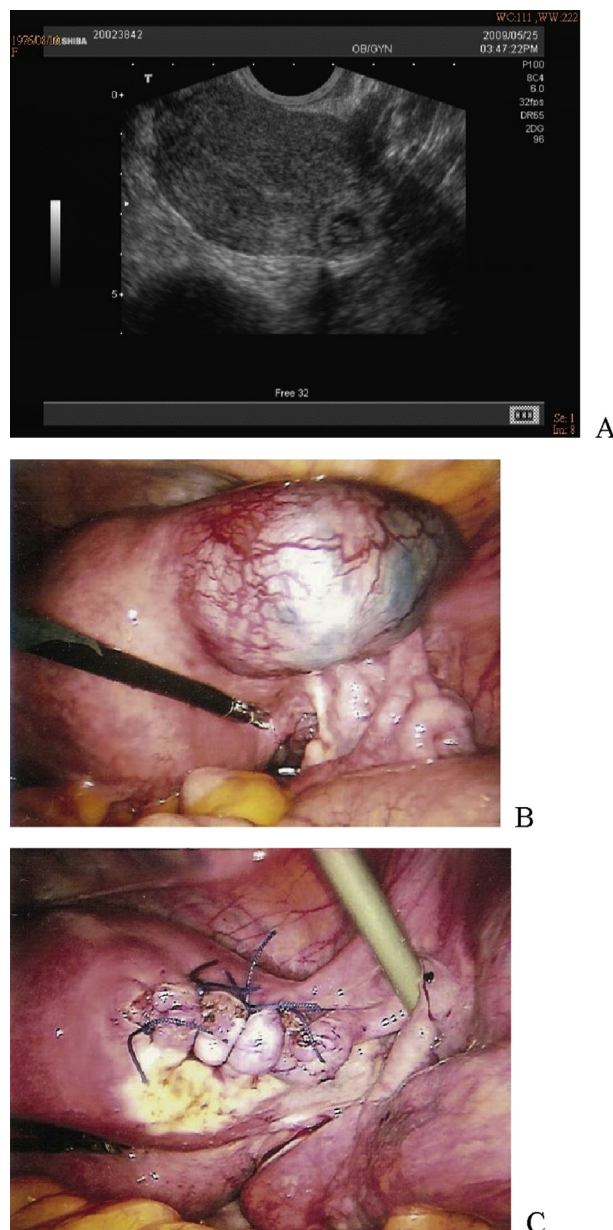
(A) A transvaginal ultrasound image showing an extremely eccentrically located gestational sac and an empty endometrial cavity. (B) An extremely eccentrically located ectopic mass with increased vascularization covered with thin myometrium. (C) A single layer of interrupted 2-0 polyglactin sutures placed in the cornuostomy site.
